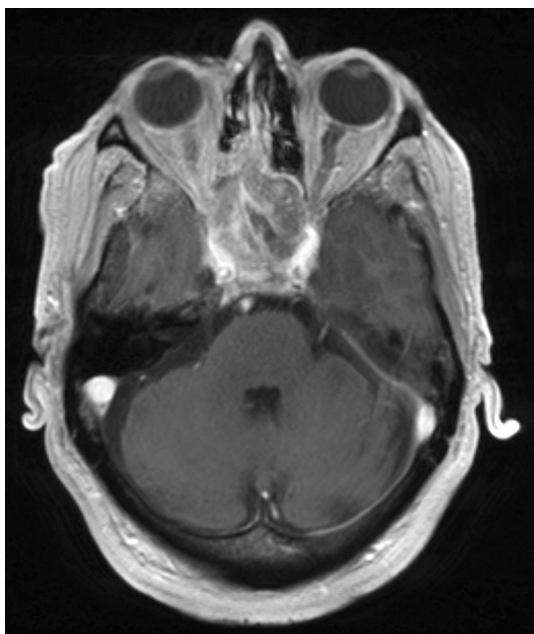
Axial magnetic resonance imaging (MRI) showing a large irregular mass filling the right sphenoidal sinus and laterally displacing the right sphenoid lamina papyracea
